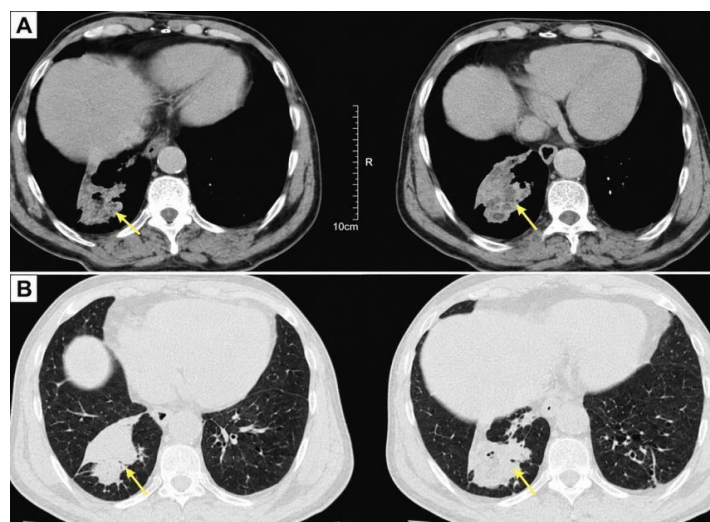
Axial chest CT images showing an irregular, heterogeneous tissue consolidation in the right lower lobe
